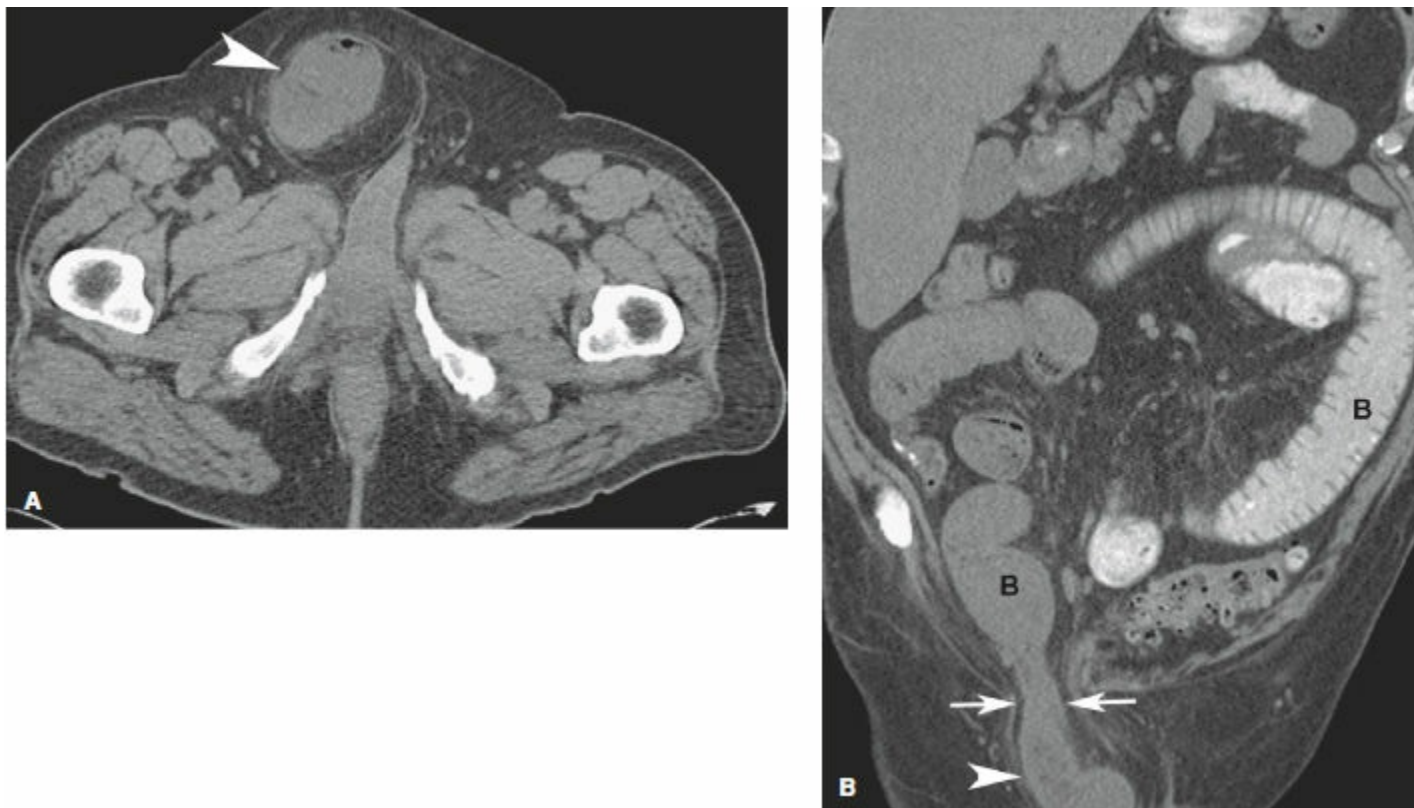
Computed tomography images of an inguinal hernia. Axial (A) and coronal (B) CT scan images showing incarcerated right inguinal hernia with air- and fluid-filled loop of small bowel (arrowhead) in the right inguinal canal (arrow) causing small bowel obstruction with dilated loops of proximal small bowel (B).
